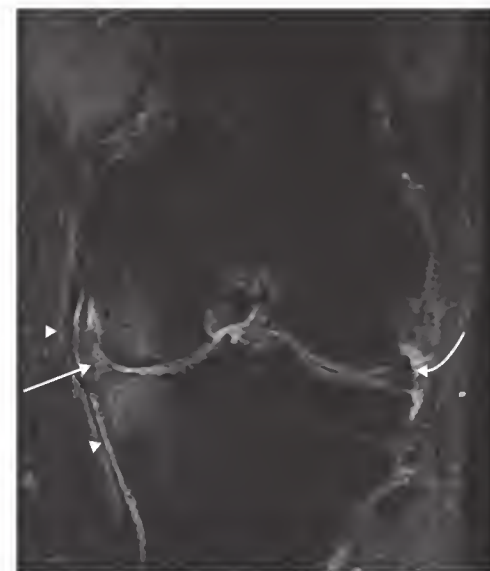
Coronal T2-weighted fat-suppressed magnetic resonance image of the knee demonstrating bone marrow lesion and cartilage loss on both sides of the medial joint. The medial meniscus is markedly degenerate with maceration and abnormally increased signal (straight arrow) compared with the normal lateral meniscus (curved arrow). Abnormally increased signal is also seen on both sides of the medial collateral ligament (arrowheads).
